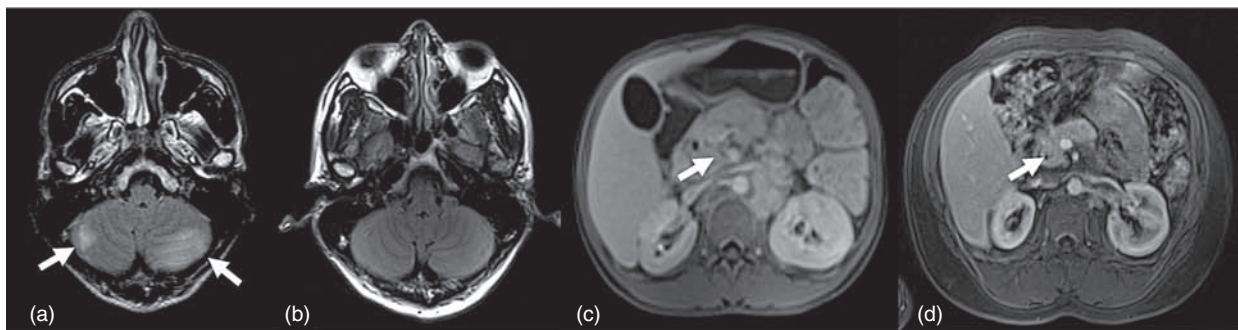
Axial cerebral MRI in fluid-attenuation inversion recovery sequences (case 1) and axial abdominal MRI (case 3) in T2-weighted sequences following the diagnosis of a relapse immune reconstitution inflammatory syndrome and with treatment (steroid and thalidomide). (a) Bilateral cerebellar hyperintensity in September 2009 (arrows). (b) Disappearance of cerebellar hyperintensity in October 2011 after 14 months of thalidomide (100 mg per day). (c) Voluminous mass encircling the mesenteric vessels in August 2010 (arrow). (d) Major decrease in the size of abdominal mass in January 2011 after 3 months of thalidomide (100 mg per day) (arrow). FLAIR, fluid-attenuation inversion recovery; IRIS, immune reconstitution inflammatory syndrome.
